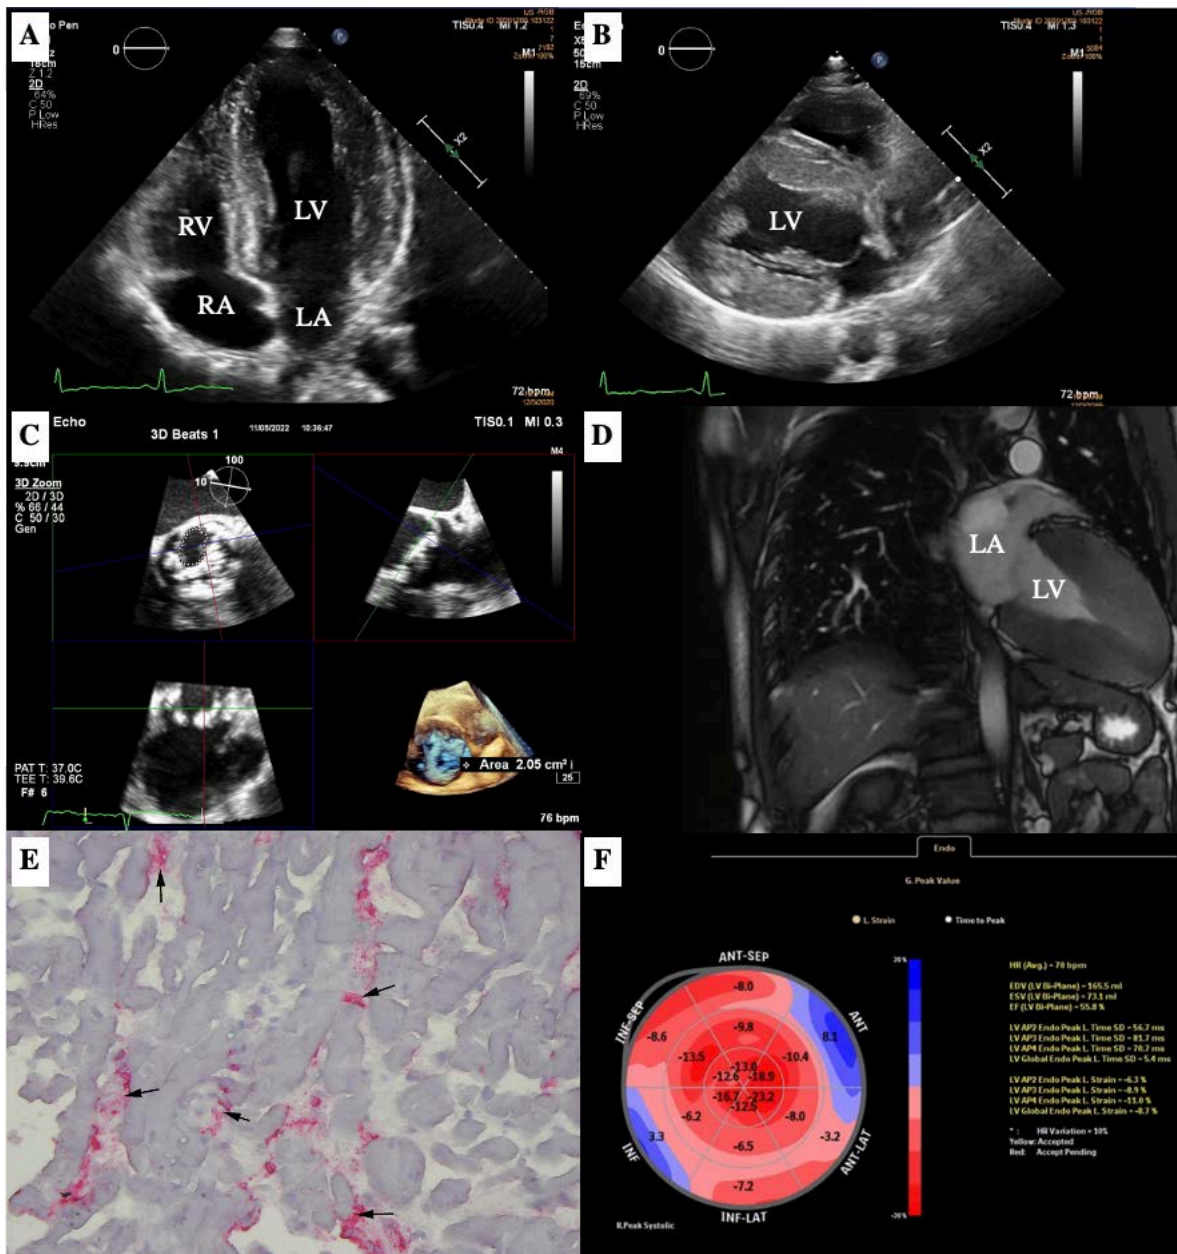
A. TTE, four-chamber view. B. TTE, parasternal long axis view. C. TEE, 3D acquisition and multislice assessment of aortic valve area. D. CMR with contrast. E. Endomyocardial biopsy demonstrated patchy distributed of CD68(+) macrophages (red color) with concomitant myocyte injury (the arrows) suggesting reactive inflammation; F. LV GLS, 8.7%
